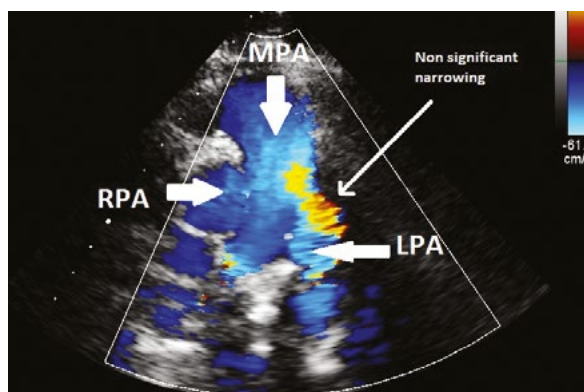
Transthoracic echocardiogram performed 20 months after the primary surgical repair. Parasternal short-axis echocardiography with color and Doppler options performed 20 months after surgery demonstrated a normal LPA origin with a small, nonsignificant narrowing. The outcome was reported as normal. MPA – main pulmonary artery
